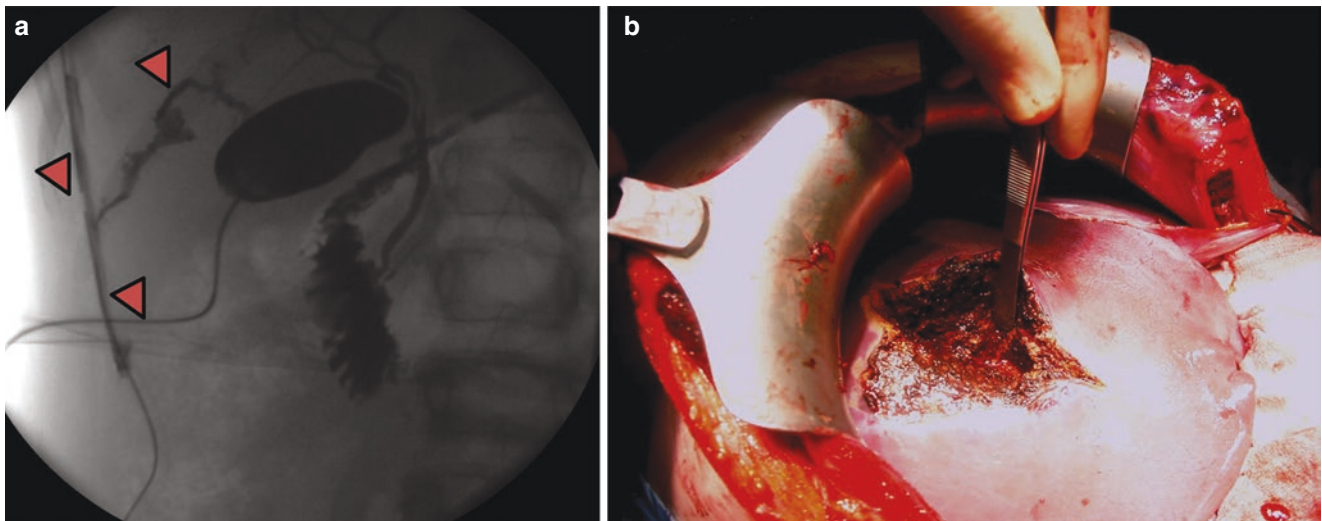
(a) X-ray of the abdomen following a direct cholecystogram showing bile leak 2 weeks post injury, with intra-abdominal drain still draining bile. (b) Laparotomy photograph demonstrating surgical haemostasis
